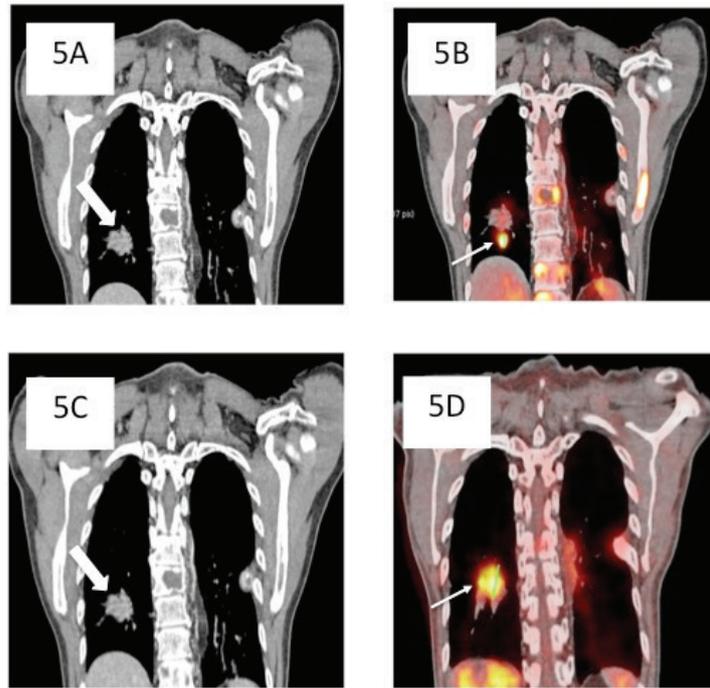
(A): Right lower lobe lung mass on CECT (thick white arrow), (B) True metabolically active lesion on coronal PET/CT images (thin white arrow) however the signal uptake is seen slightly lower than the actual lesion due to misregistration artifact; (C) CECT scan showing stable disease (thick white arrow) as assessed using RECIST criteria due to similar diameter of the lesion in baseline and follow up scans (D) PET/CT is more accurate to pick up the increasing trend of SUV_{max} reading and wider area of FDG hypermetabolism (thin white arrow), therefore confirming progressive metabolic disease (PMD) by PERCIST criteria.
